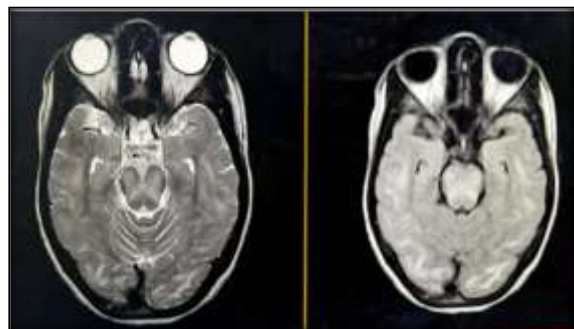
MRI Brain — Axial T2weighted (left) and FLAIR (right) images at the posterior fossa level demonstrating diffuse symmetrical hyperintense signal in the brainstem and bilateral cerebellar white matter.
